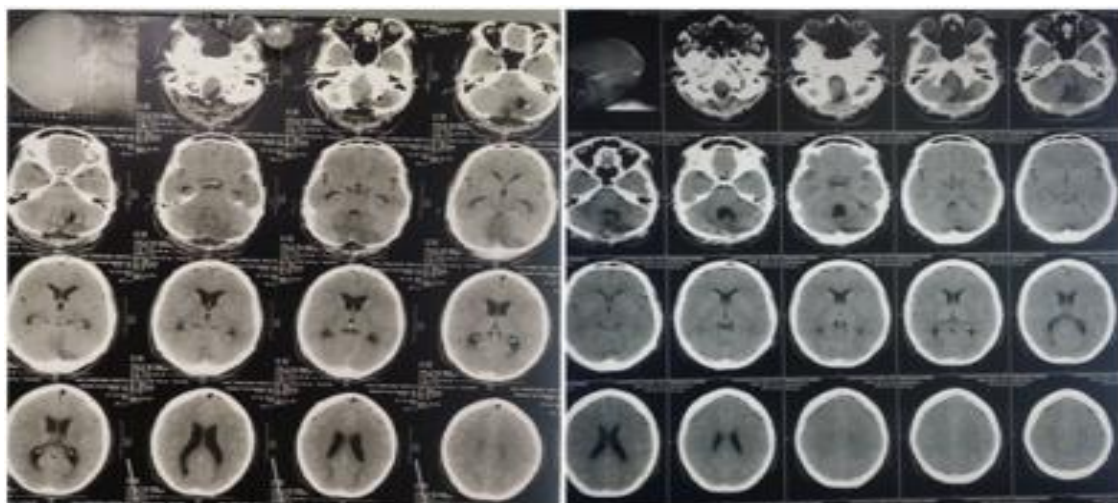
B: Postoperative and 1 month postoperative CT scans of Case 2.
